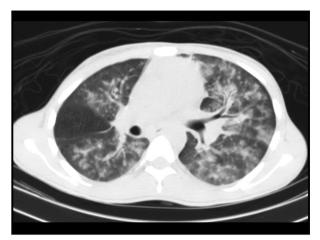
Chest CT scan revealed bilateral diffuse patchy infiltrates due to Kaposi's sarcoma.
